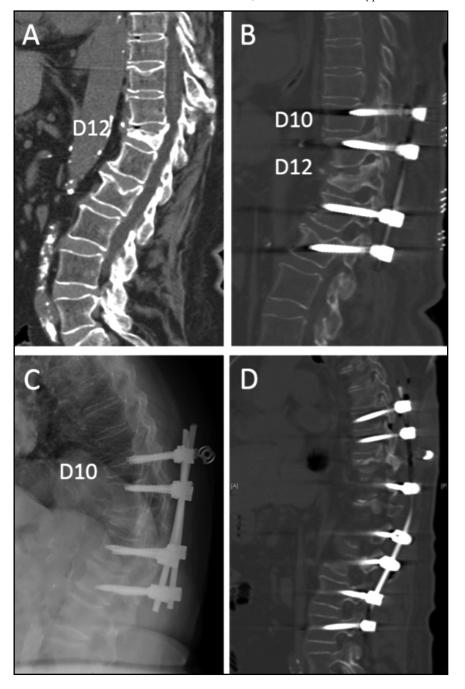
(A) Sagittal CT at the thoracolumbar level; osteoporotic compression fracture at level D12 with segmental kyphosis is observed. (B) Arthrodesis through instrumentation with pedicle screws from D10 to L2, with significant kyphosis correction. (C) Lateral radiography: vertebral compression fracture at D10 level with kyphosis of the proximal junction and screw pullout at level D10. (D) Extension of arthrodesis, superior to levels D8 and D9 and inferior to levels L3 and L4, and correction of kyphosis
